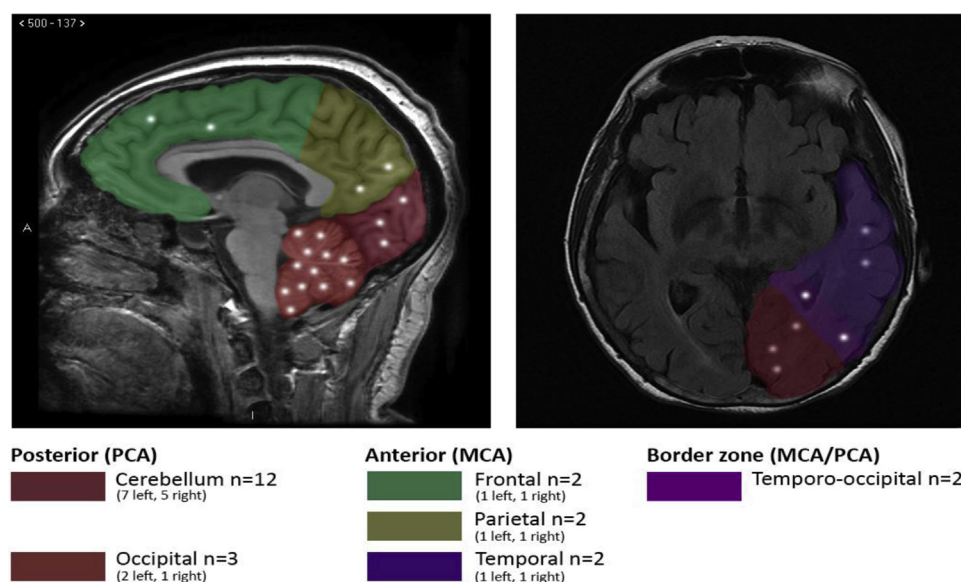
Territories of new magnetic resonance imaging lesions. MCA, Middle cerebral artery; PCA, posterior cerebral artery.
